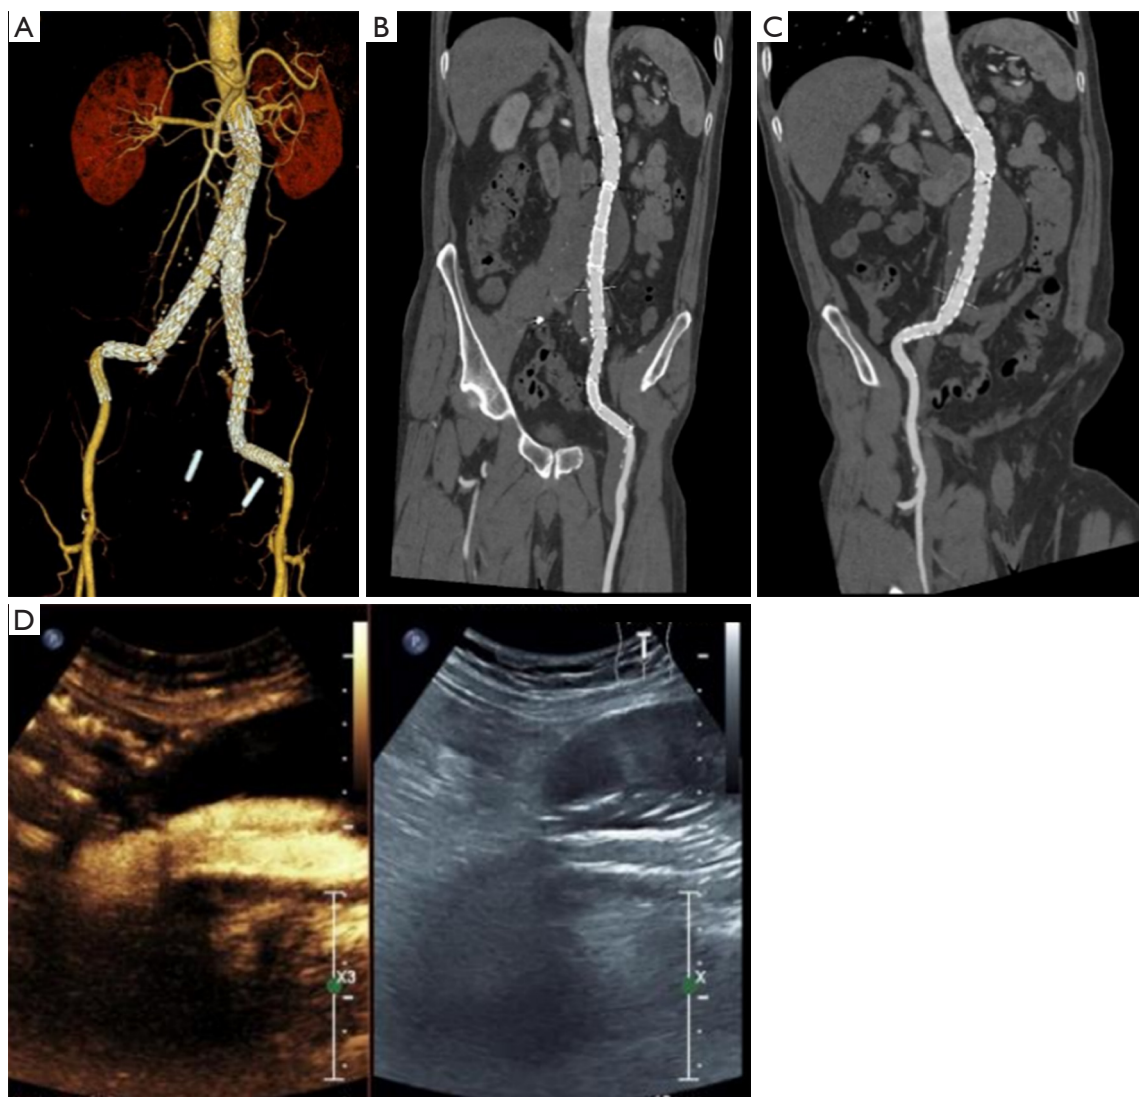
Follow-up results of CTA and CEUS after the second IBO operation. In August 2021, CTA follow-up results 2 months after the last operation (A-C). The CEUS results after stent implantation showed that the marginal laminar flow disappeared after the improvement of the angle of the proximal end of the left iliac branch (D). CTA, computed tomography angiography; CEUS, contrast-enhanced ultrasound; IBO, iliac branch occlusion.
